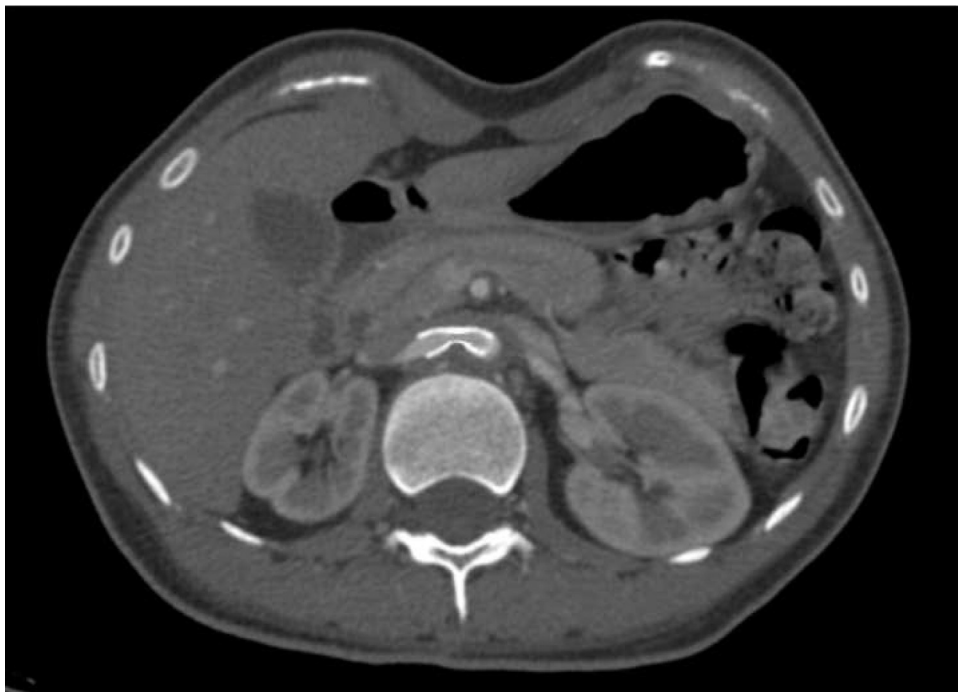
CT scan postoperative showing an improvement of kidney vascularization after stenting.
